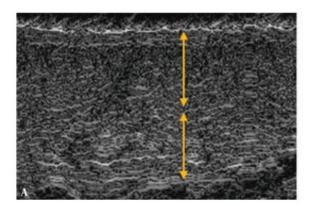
Ultrasound image of the skin
